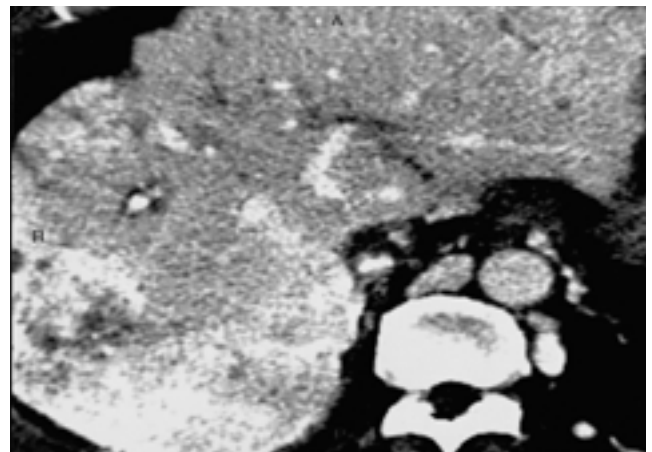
Abdominal CT shows inadequate recanalization of hepatic IVC due to residual thrombus in spite of adequate urokinase thrombolysis. And there is parenchymal uptake of lipiodol infused at that time of previous transarterial chemoembolization of hepatocellular carcinoma.
